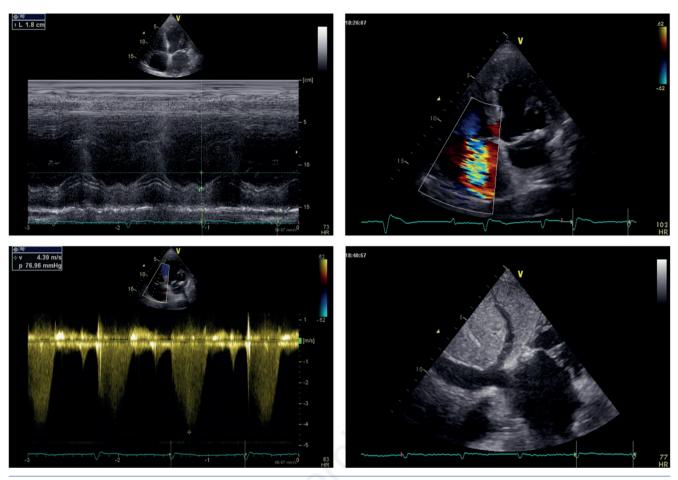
Echocardiographic evaluation of the effects of obstructive sleep apnea syndrome on pressure variations of the pulmonary circulation and right ventricle.
